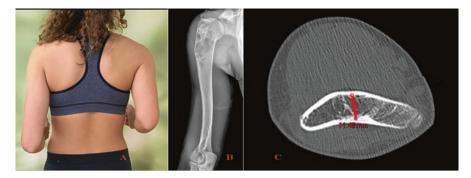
Pre-op situation. (a) Right humeral discrepancy. (b) Pre-op x-ray showing unicameral bone cyst in proximal humerus. (c) AP dimension of distal humerus is large enough for a narrow femoral nail
